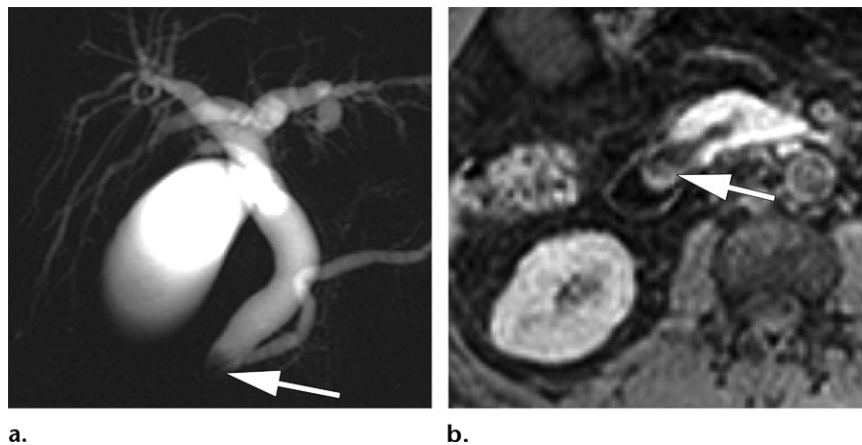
Peripapillary neoplasm (adenoma) in a 42-year-old man. (a) MR cholangiopancreatogram shows a dilated biliary tree, a prominent pancreatic duct, and an ill-defined filling defect in the distal common bile duct (arrow). (b) Axial contrast-enhanced T1-weighted MR image shows a heterogeneous enhancing nodular lesion at the papilla (arrow).
